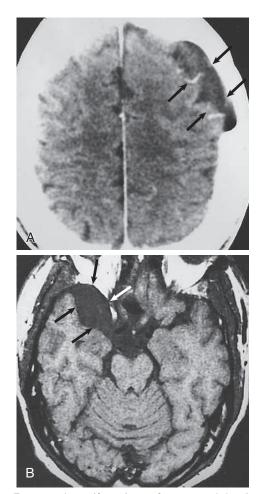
Extrarenal manifestations of autosomal dominant polycystic kidney disease (ADPKD). Computed tomography (A) and magnetic resonance imaging (B) scans demonstrate cysts in the arachnoid membrane (arrows) in ADPKD.
